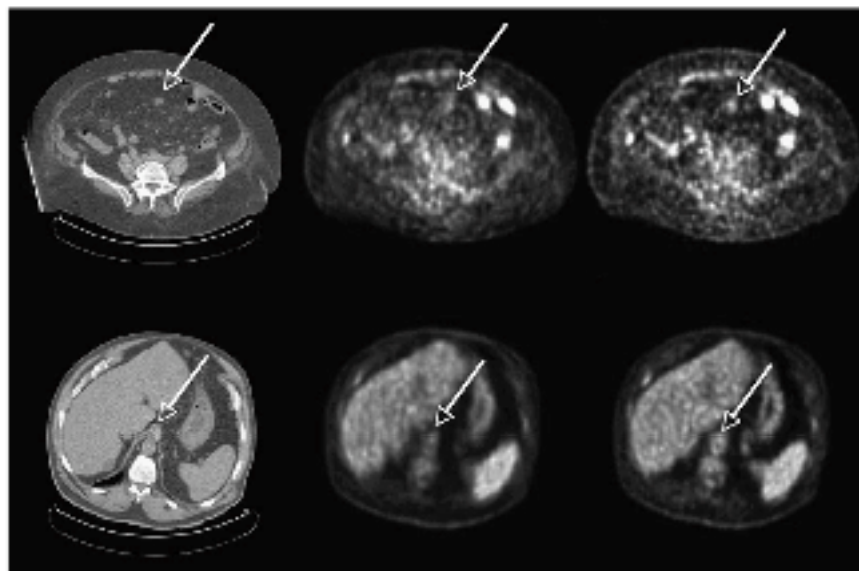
Representative transverse sections of 2 different patients: low dose CT (left), non-TOF MLEM (middle), and TOF MLEM (right). (Top) Patient 1 with colon cancer (119 kg, BMI = 46.5) shows a lesion in abdomen seen in CT much more clearly in TOF image than in non-TOF image. (Bottom) Patient 2 with abdominal cancer (115 kg, BMI = 38) shows structure in the aorta seen in CT much more clearly in TOF image than in non-TOF image.
